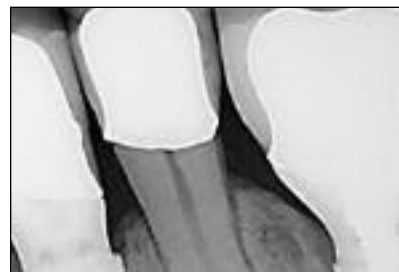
Standardized radiograph at 12 months of follow-up.
